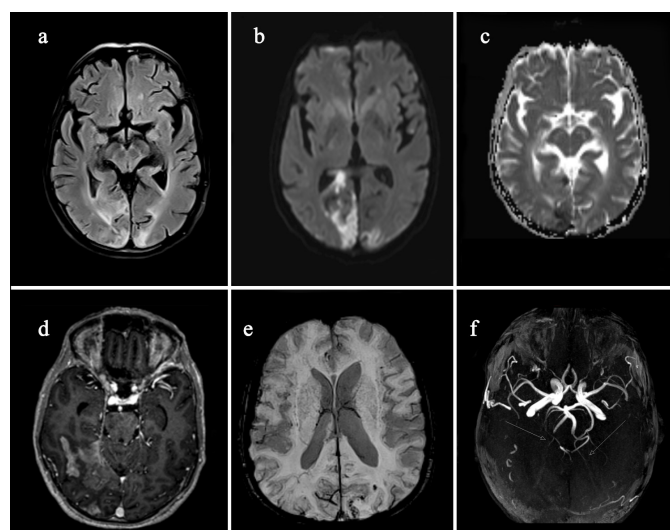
(a) Bilateral parieto-occipital cortical and subcortical hyperintensities on FLAIR; (b, c) DWI and corresponding ADC map show restricted diffusion together with areas of T2 shine-through in these regions; (d) Contrast-enhanced T1-weighted image demonstrates a gyral enhancement pattern in the right temporo-occipital region; (e) SWI reveals a few punctate blooming artifacts representing small hemorrhagic foci in the left parietal cortex; (f) Non-contrast MRA demonstrates absence of the distal P2 segments of both posterior cerebral arteries.
